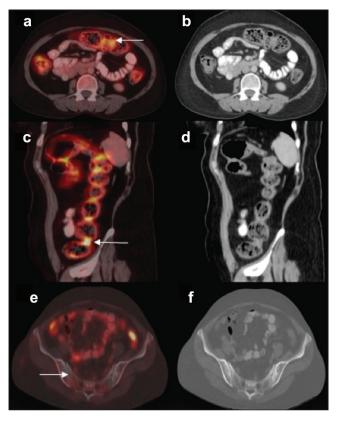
(a and b) Transaxial fused and corresponding CT showing abnormal FDG avid foci (SUV $_{\rm max}$ 10.6 vs liver SUV $_{\rm max}$ of 4.5) in the transverse colon (arrow). (c and d) Sagittal fused and corresponding CT showing abnormal FDG avid foci (SUV $_{\rm max}$ 12.6 vs liver SUV $_{\rm max}$ 4.5) in the descending colon (arrow). (e and f) Transaxial PET/CT images showing sclerosis in both the sacroiliac joints (arrow).
